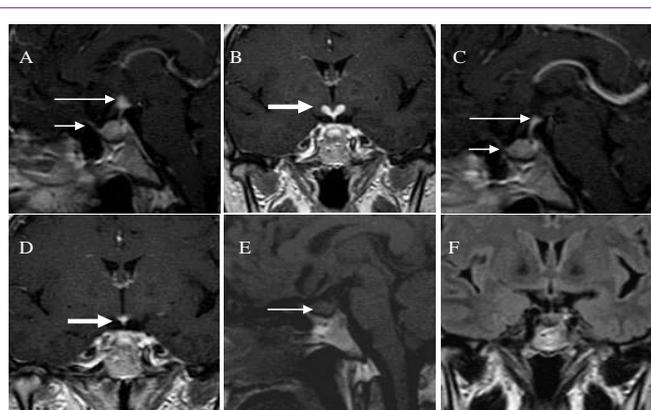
MRI images over time of 50-year-old female patient with infundibulo-hypophysitis.
